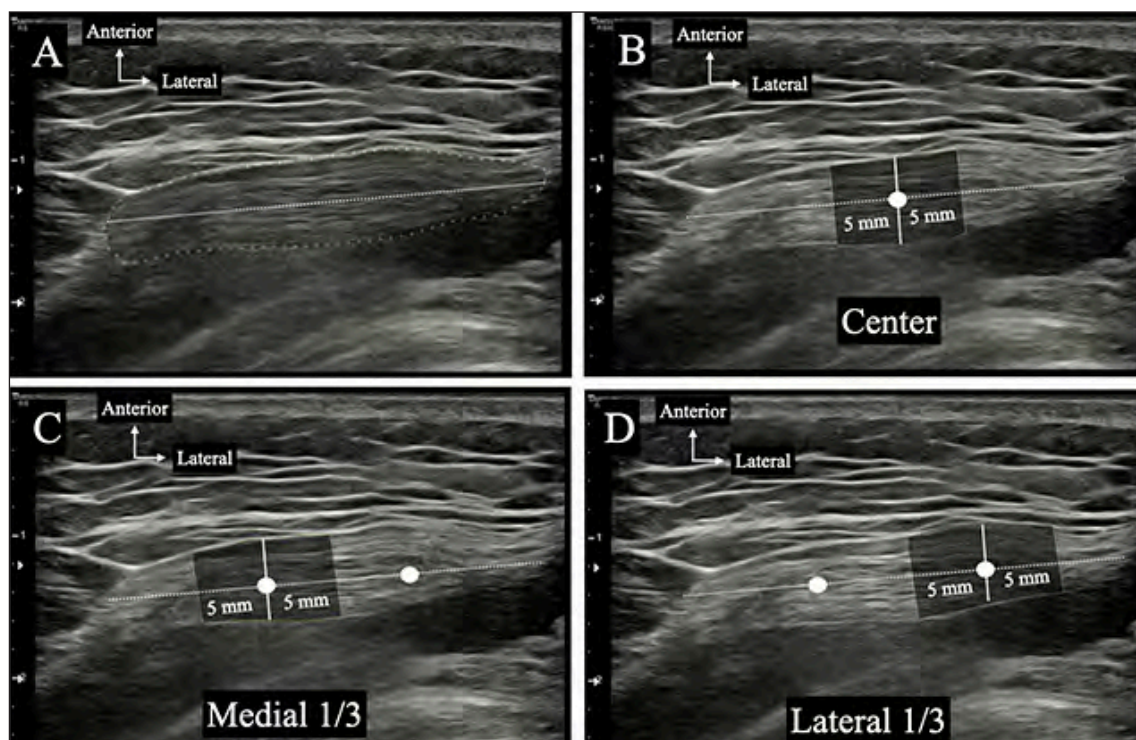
Ultrasonographic measurement of cross-sectional area (CSA) and thickness of quadriceps tendon (QT) at three different points. CSA was measured with a width of 10 mm. A. The width was measured parallel to the tendon at the widest diameter of the QT; B. The center of the QT; C. Medial one-third of the QT; D. Lateral one-third of the QT
